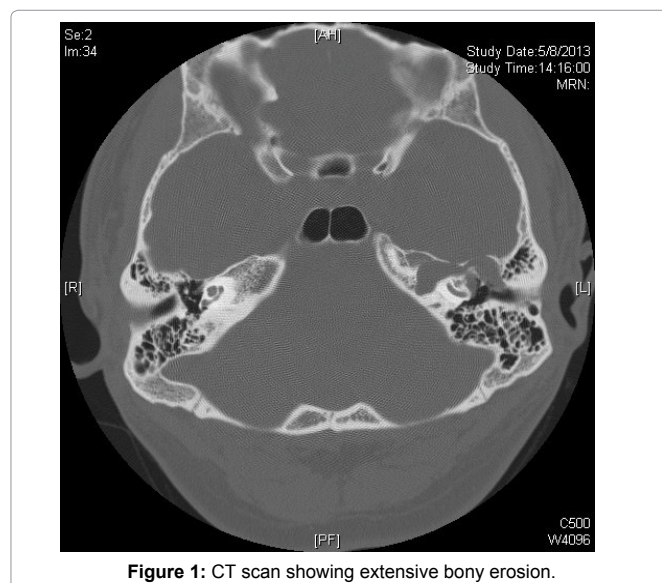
CT scan showing extensive bony erosion.
